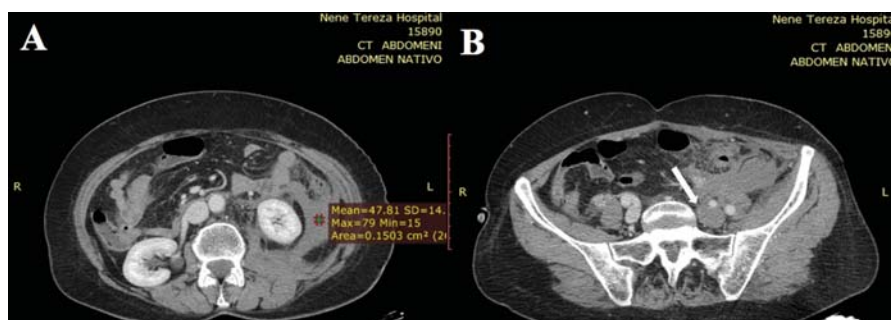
Contrast-enhanced computed tomography showing retroperitoneal hematoma (A), distention and thrombosis of left common and external iliac veins (B)
